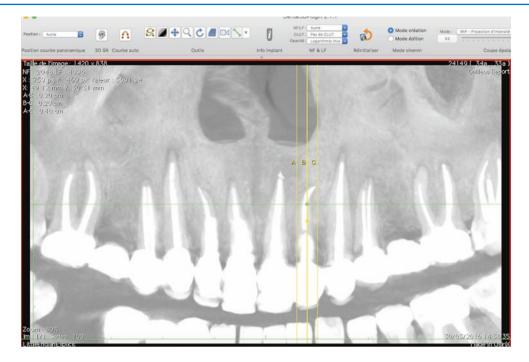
A radiographic image downloaded from an online implant forum accompanied by the following text: "... a case of a patient complaining about pain and recurrent periapical infection on her six anterior teeth. She is asking for implant restorations replacing the six anterior teeth and a fixed provisional restoration. What would you do in this a case?... first thoughts are to first proceed to the extraction of the four upper incisors and graft the socket of the central incisors, wait for 8 weeks and then place implants on the socket of the lateral incisors
